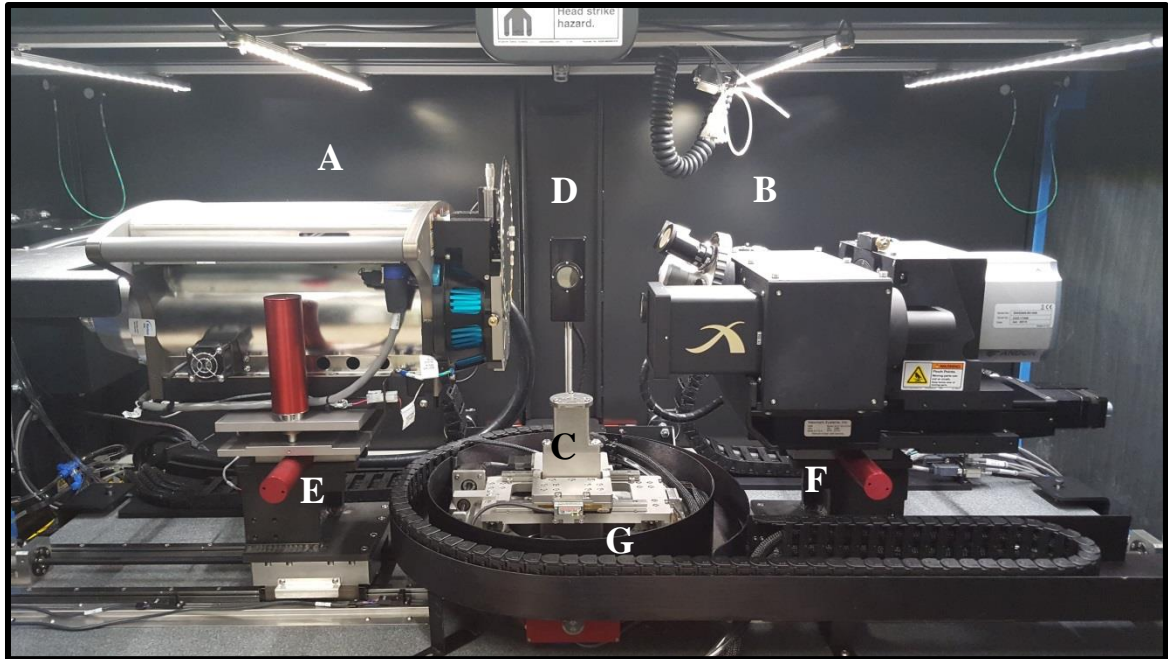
Interior of Versa scanner. A – X-ray Source, B – Adjustable objective setup, C – Rotating sample stage, D – Light and camera for video feed, E – Source movement motors, F – Detector movement motors, G – Sample movement motors.
